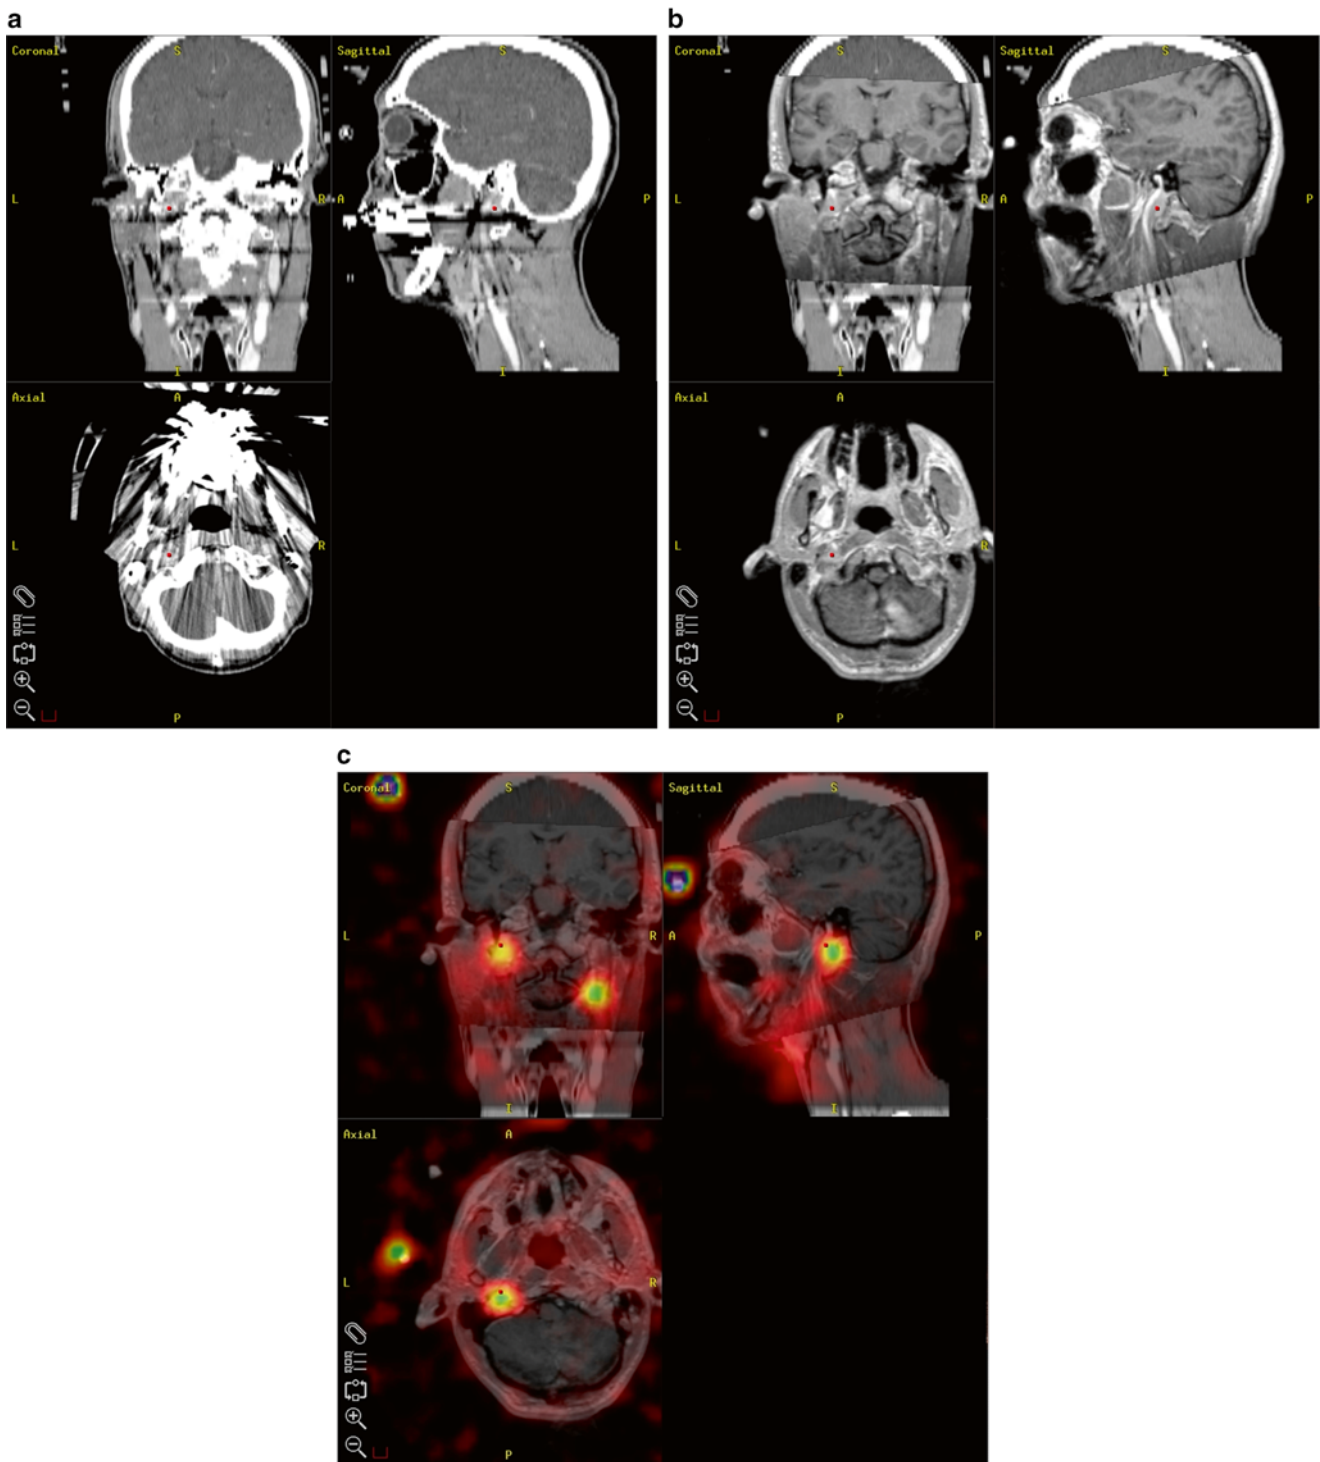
This right sided incidental jugular glomus tumor was detected on ^{99m}Tc -octreotide SPECT imaging (*bottom* in fusion with MRI) after being missed on both CT (*top*) and MRI (*middle*) for a left
